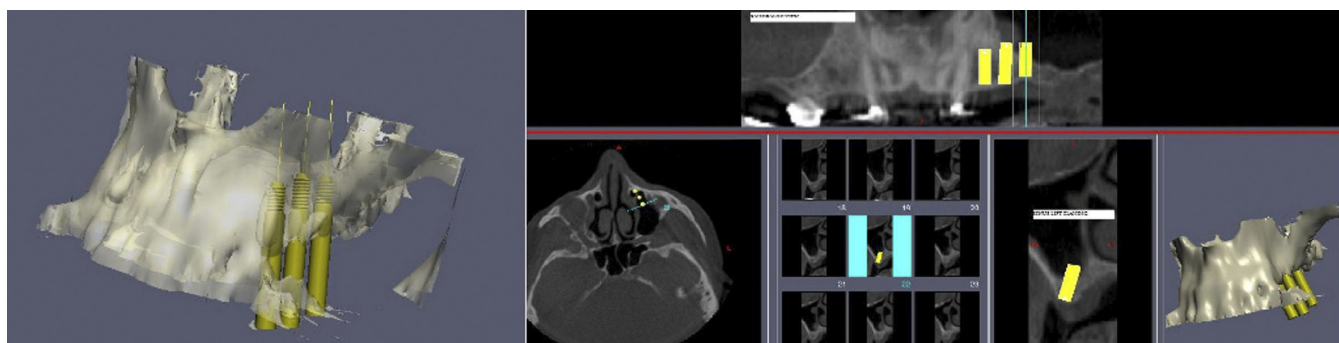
Detailed planning of patients was conducted by using three-dimensional implant software over cone-beam CT data.
